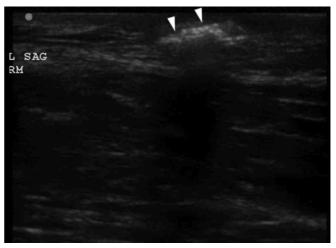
Subcutaneous air on the EFAST exam of the thorax. From Figure 5A of Buttar S, Cooper D Jr, Olivieri P, et al. Air and its sonographic appearance: understanding the artifacts. *J Emerg Med.* 2017;53(2):241–247.
